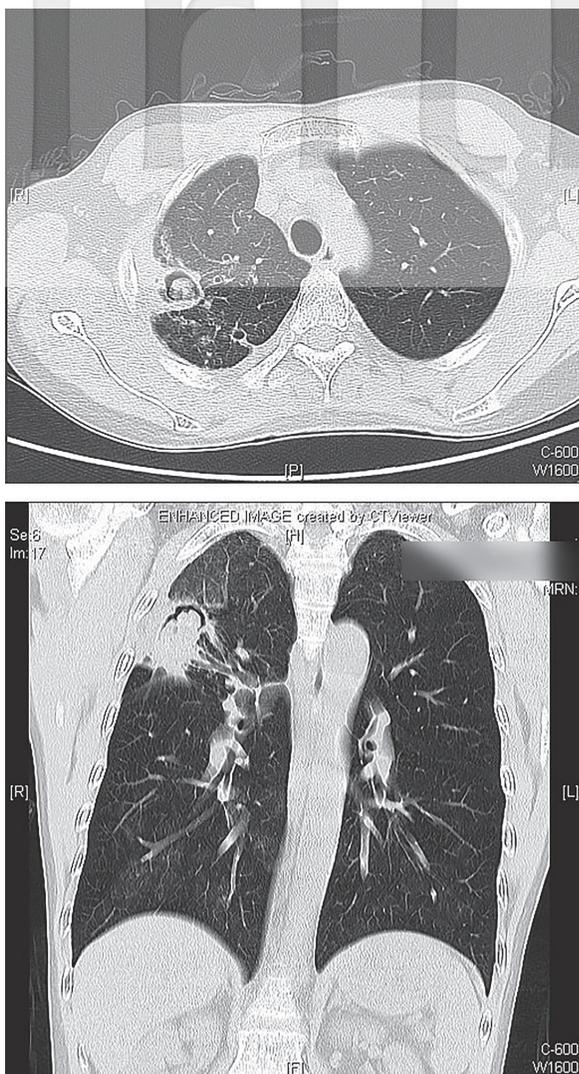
In cross-sectional and reconstructed coronal computed tomography (CT), a round, soft tissue mass is seen in the cavity. This heterogeneous mass is in a dependent position with an adjacent crescent of air, which is so called “ball in a hole,” a characteristic image finding of pulmonary aspergilloma. Local, extensive thickening of pleura can also be identified.
